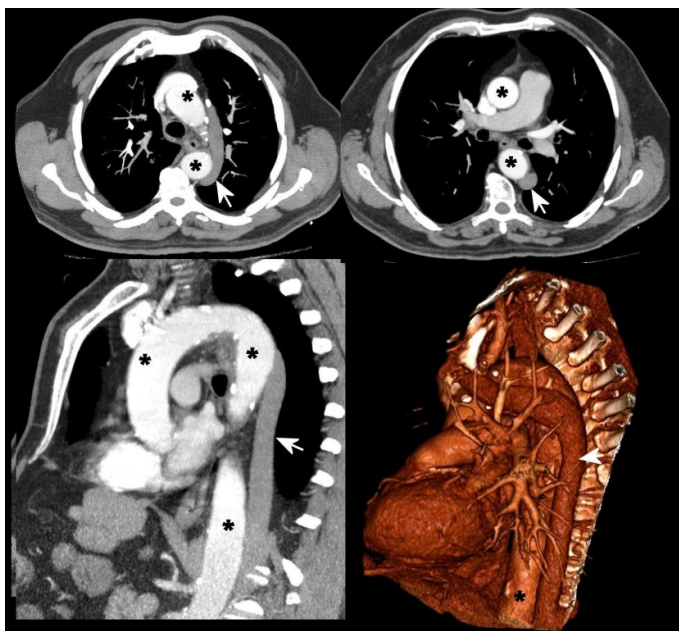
(Thorax CT scan and 3D reconstruction): Absence of the inferior vena cava and dilated hemiazygos vein. *Aorta, → Hemiazygoz
